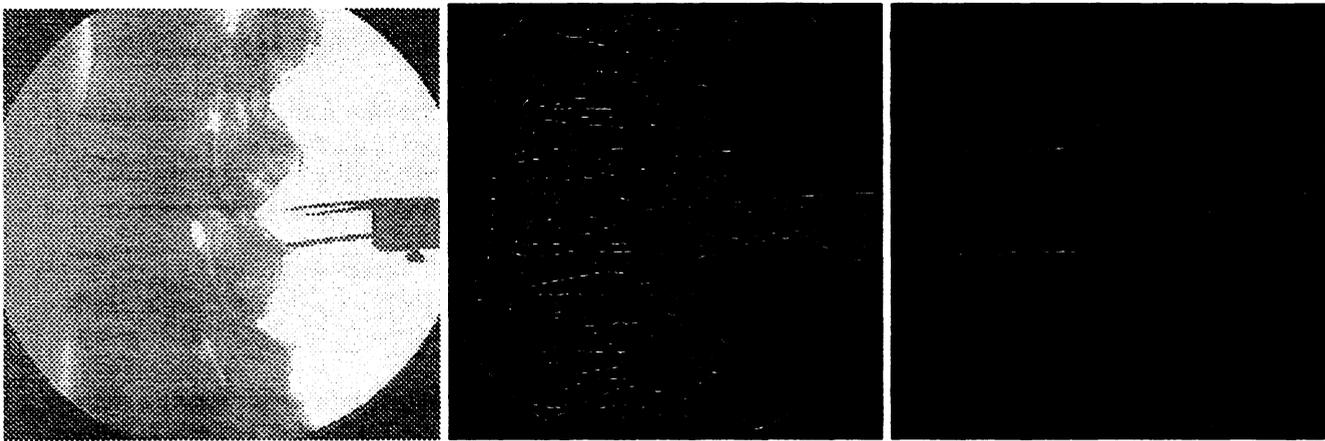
X-ray images of the spine : (a) original imag, (b) pre-segemented images using the Canny-Derliche filter followed by local maxima extraction and hysteresis thresholding, (c) labelled image
